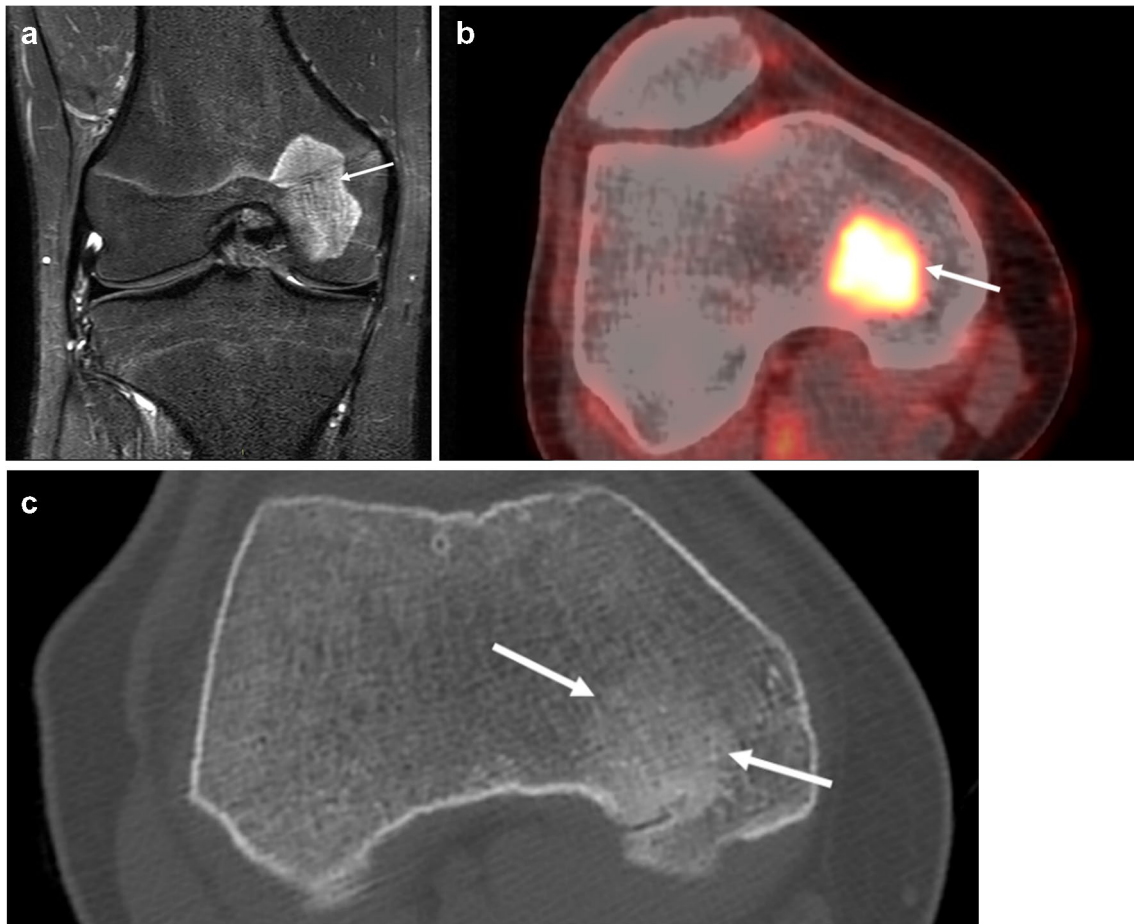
Images of a 13-year-old boy with an asymptomatic focal bone lesion incidentally detected on a knee magnetic resonance imaging (MRI) performed after a sprain injury of the knee. A well-defined lesion on the distal epiphysis of the right femur (*arrow*) is displayed on MRI coronal view of the knee T2w fat saturated (a). Positron
